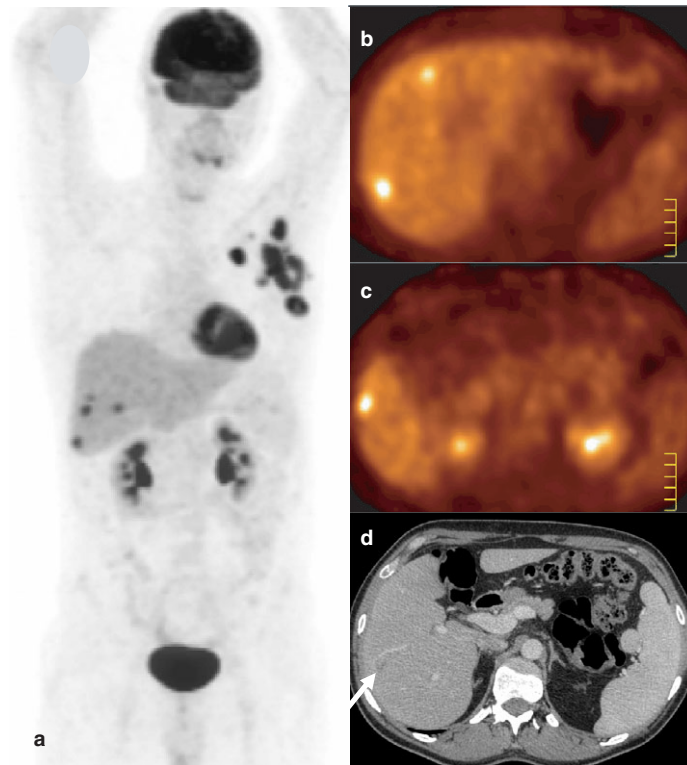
A 36-year-old patient with aggressive non-Hodgkin's lymphoma who initially presented with a huge left axillary mass and partial response at completion of first-line chemotherapy. At re-staging 10 months later (a–c), PET/CT with FDG demonstrates, in addition to local residual disease over the left axillary region, at least four occult hepatic lesions (fused-CT images not shown). Only one of the lesions (arrow) can be retrospectively identified on the contrast-enhanced abdominal CT performed 9 days earlier (d). The patient's condition deteriorated rapidly after the PET/CT exam.
